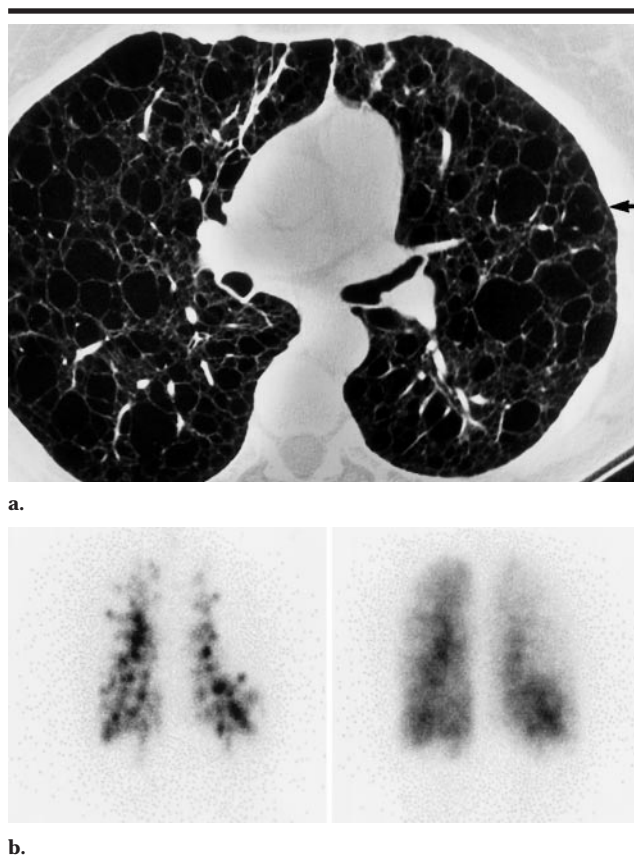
Lymphangioleiomyomatosis in a 52-year-old woman. (a) Transverse thin-section CT scan and (b) posterior ventilation (left) and perfusion (right) images show the severe extent of disease visible on the CT scan, which consists of pulmonary cysts (arrow) involving more than 60% of the lungs, severe ventilation and perfusion abnormalities, and marked speckling consisting of multiple areas of increased uptake of radionuclide that extend to the periphery throughout both lungs.
